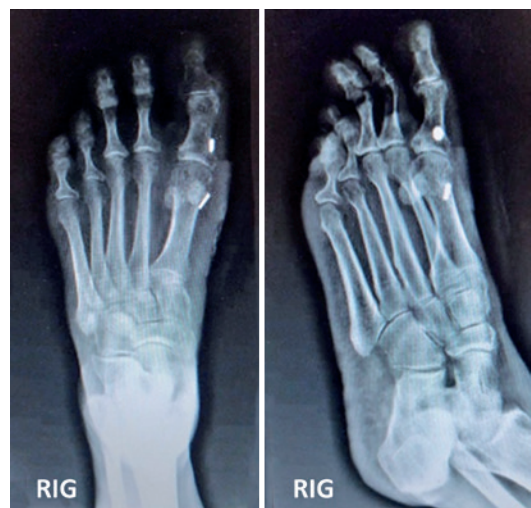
Anteroposterior and oblique postoperative radiographs.
